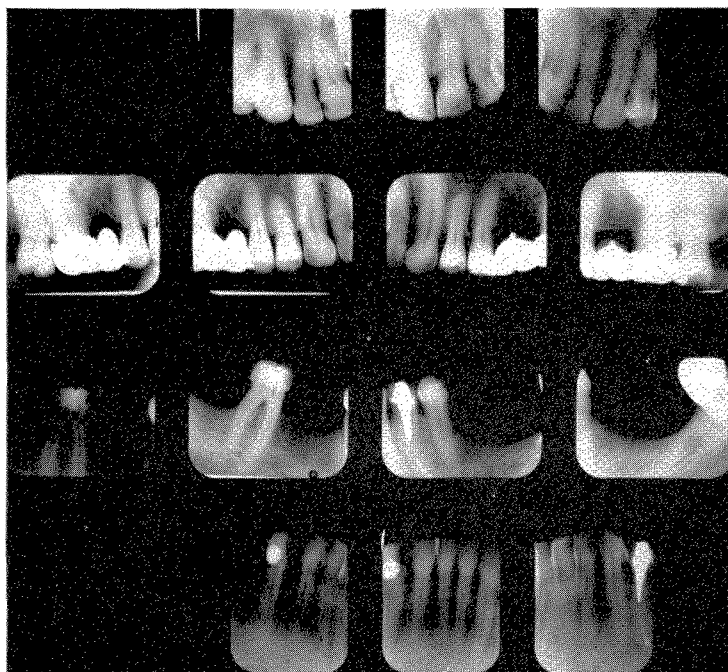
Roentgenograms taken in 1943 when the patient was first examined at the age of 54 years. (Figs. 445 to 454 are of the same case.)
